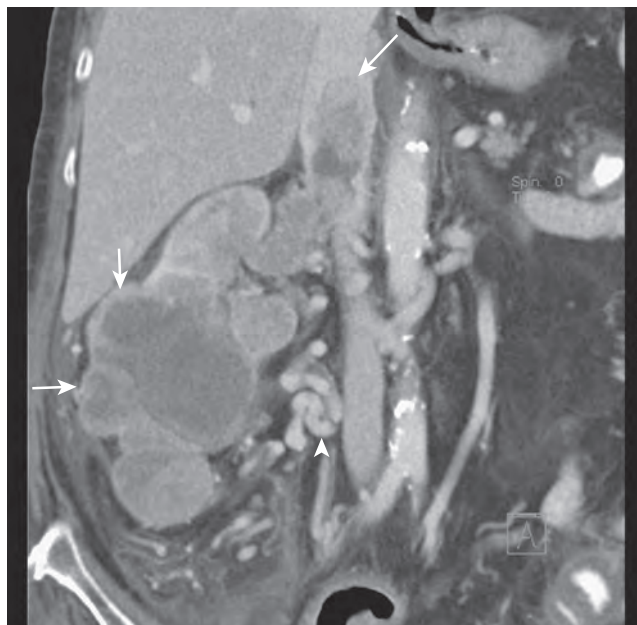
Computed tomography scan demonstrating lower pole right renal cell carcinoma (*short arrows*) with level III inferior vena cava (IVC) thrombus. The *long arrow* indicates the upper extent of the tumor thrombus within the intrahepatic portion of the IVC. The *arrowhead* indicates extensive retroperitoneal venous collateral vessels associated with restricted flow within the IVC.
